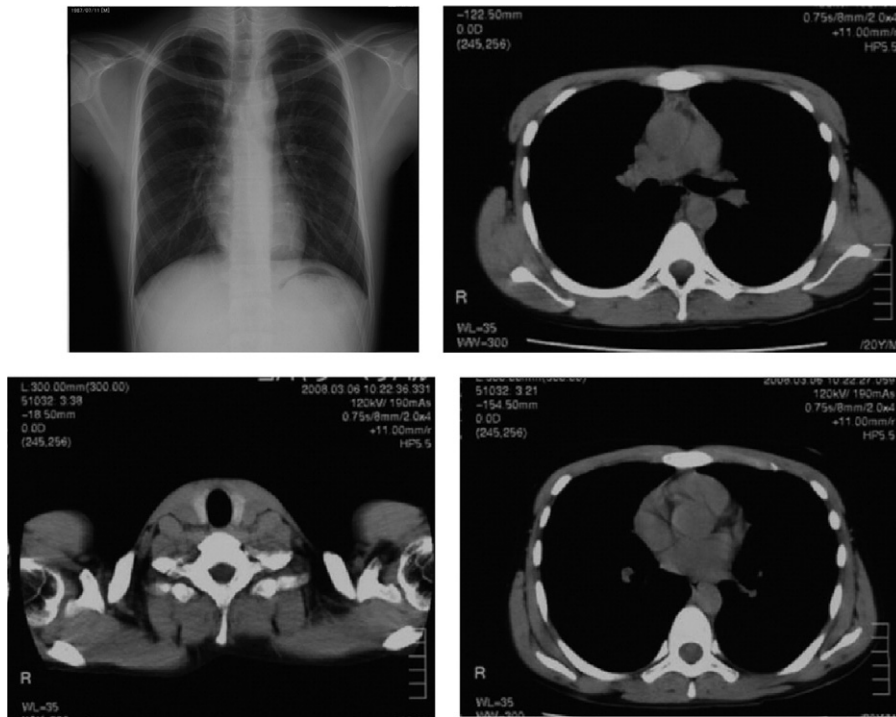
On the first consultation, no abnormal findings were recognized on the chest radiograph or computed tomography scans.
